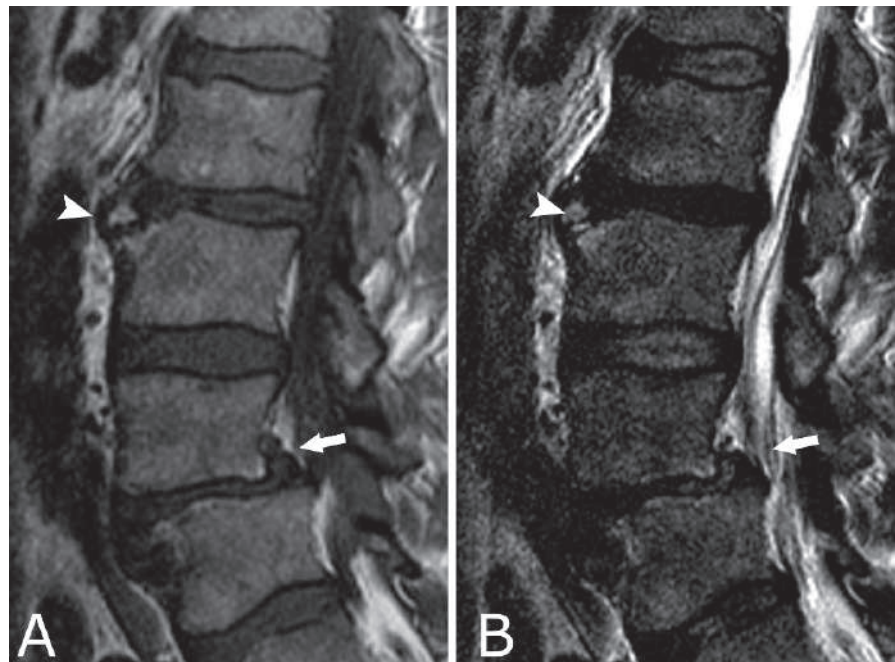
Sagittal T1W (a) and T2W (b) MRI of a patient with vertebral column osteochondrosis shows L2 limbus vertebra (arrowheads) and L4/L5 grade 1 ($<25\%$) spondylolisthesis (arrows). Notice the active bone marrow edema around the bone fragment of the anterior superior end plate of L2 in (b)
